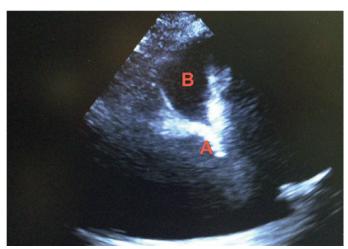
(A) Hyperechoic area on lung ultrasound representing alveolar collapse and consolidation. (B) Hypoechoic area on lung ultrasound representing pleural effusion.
